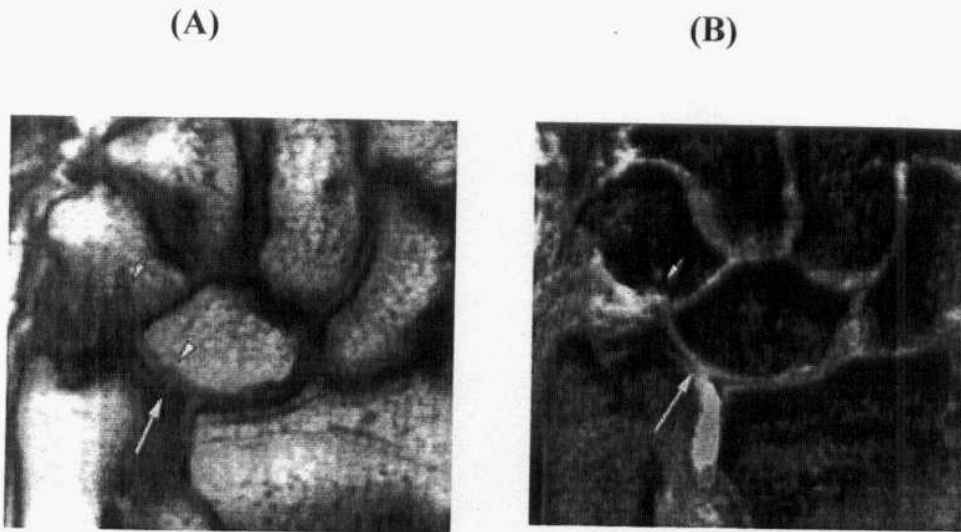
Ulnar impaction syndrome in a 32-year-old woman with significant positive variance and insidious onset of ulnar-sided pain Coronal T1-weighted (repetition time msec/echo time msec = 500/15) (A) and gradient-echo (B) MR images show marked positive ulnar variance, central perforation of the TFC (long arrow), and chondromalacia of the lunate bone (arrowhead in a) and triquetral bone (short arrow). An arthroscopic "wafer" procedure was performed, with excellent results(Quoted from Cerezal, et al., 2002).
